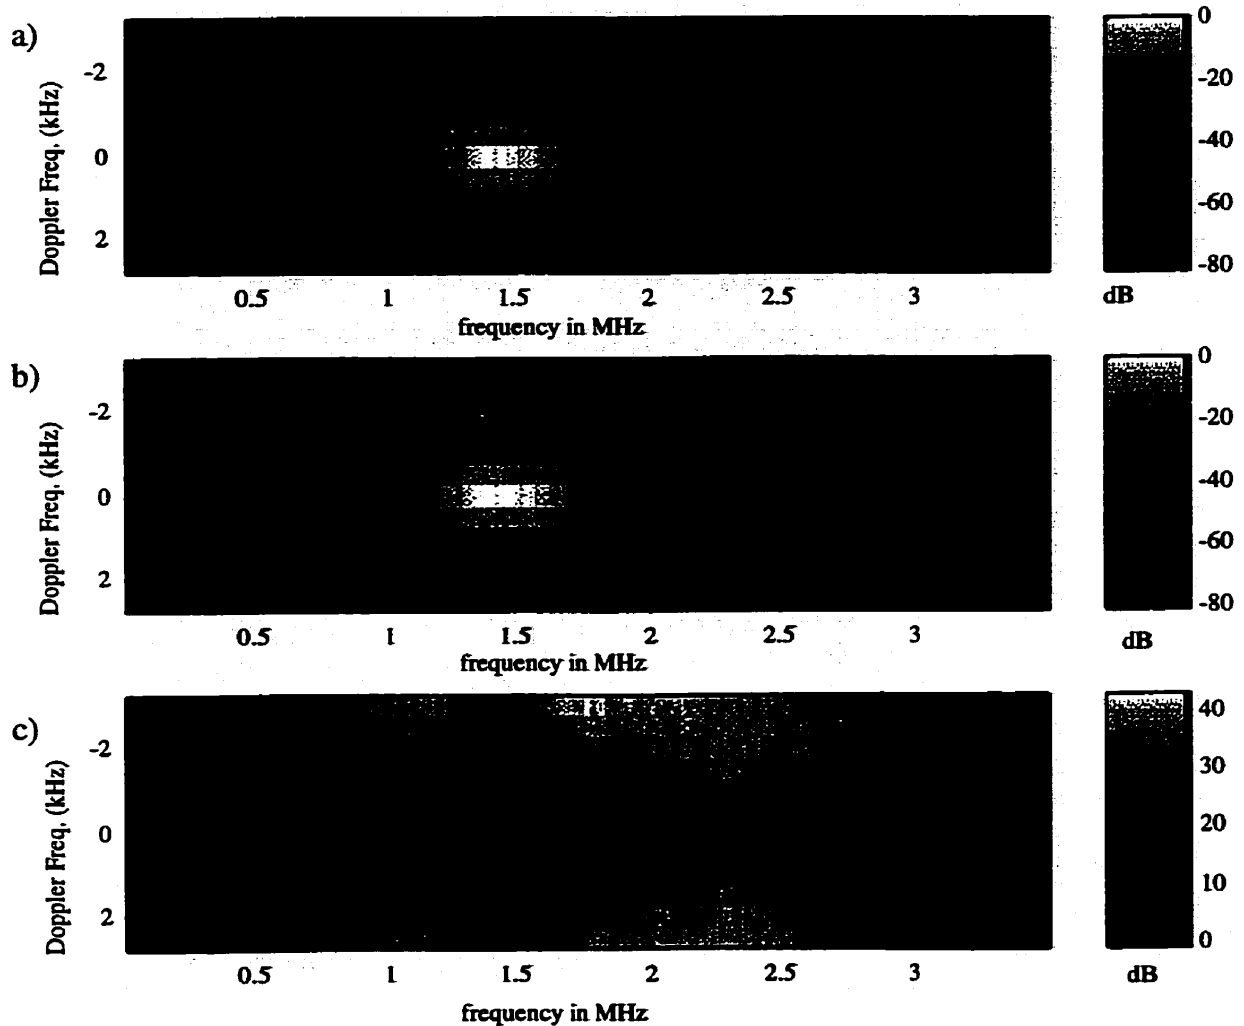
Intensity of Doppler echoes from the heart at an MI of 1.0 as a function of radio and Doppler frequency: a) baseline b) after the addition of 20 µl/kg Optison™; c) gain in signal strength vs radio and Doppler frequency.
